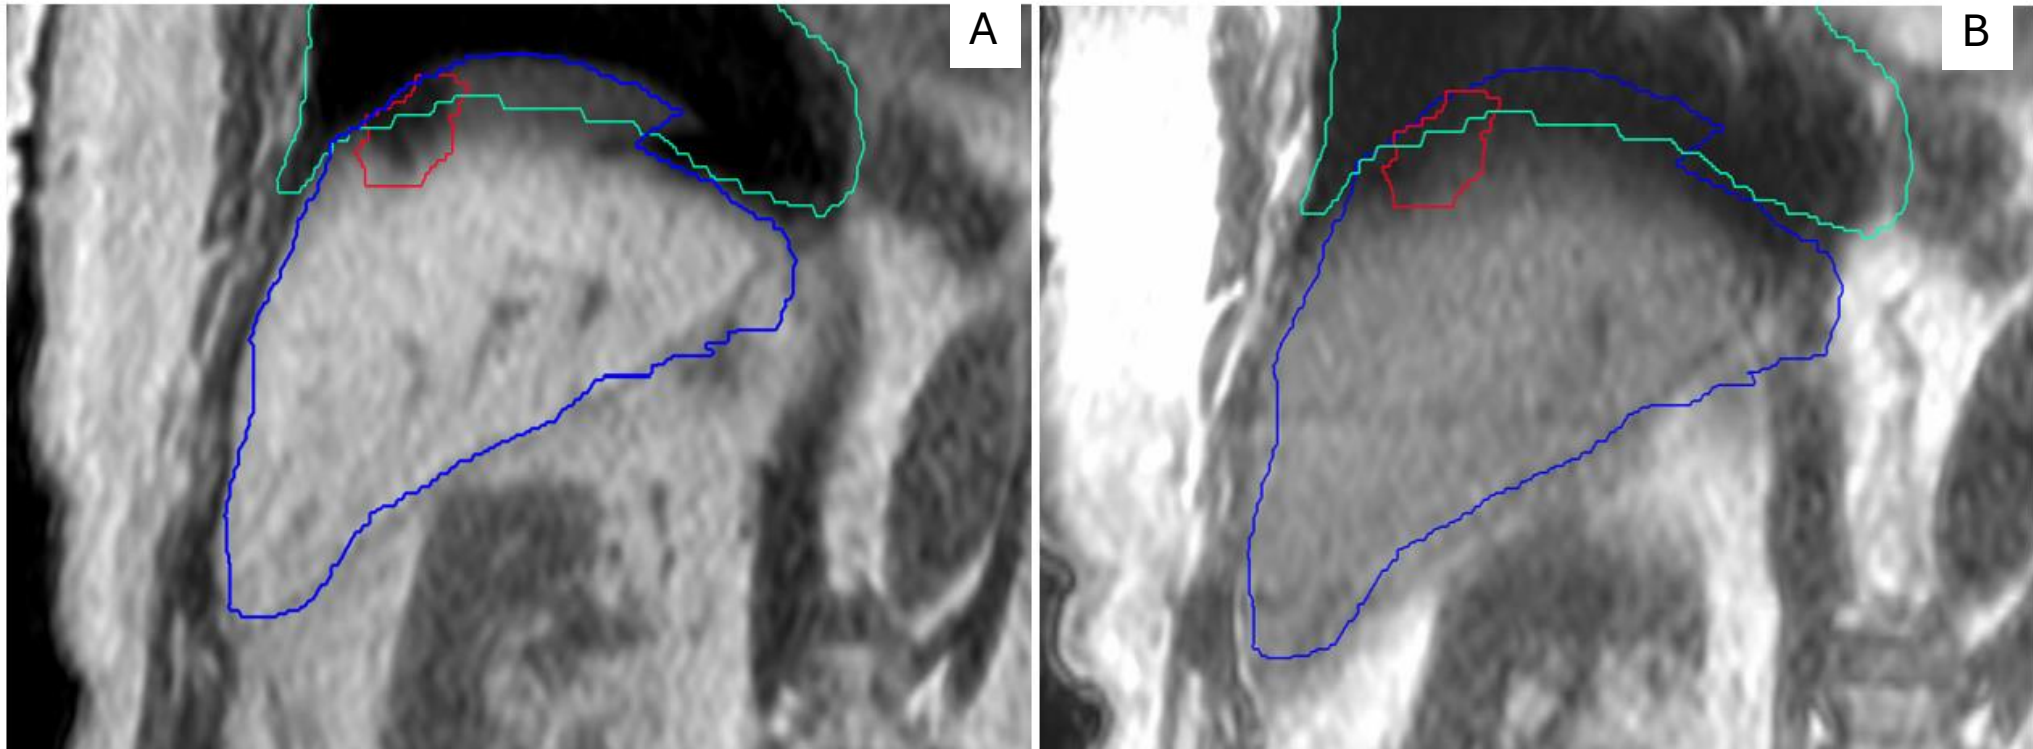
(a-b): Sagittal MR images acquired on consecutive treatment days demonstrating inter-fraction anatomical variation in the liver (orange) and associated GTV (red).
